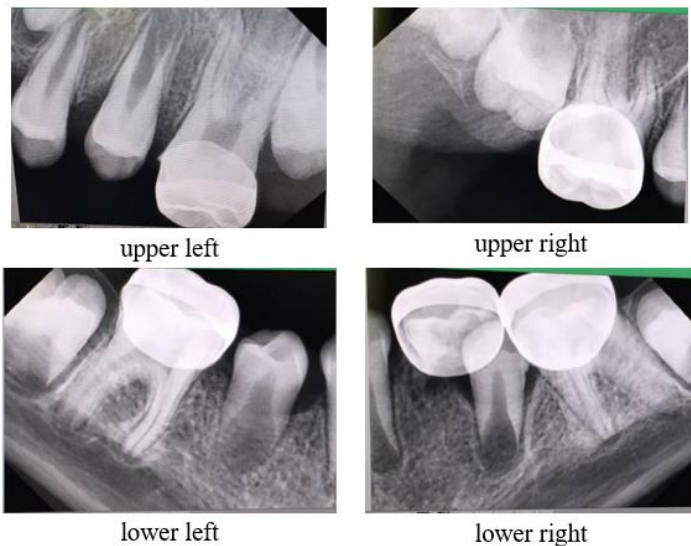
Apical radiography after three years follow-up.
